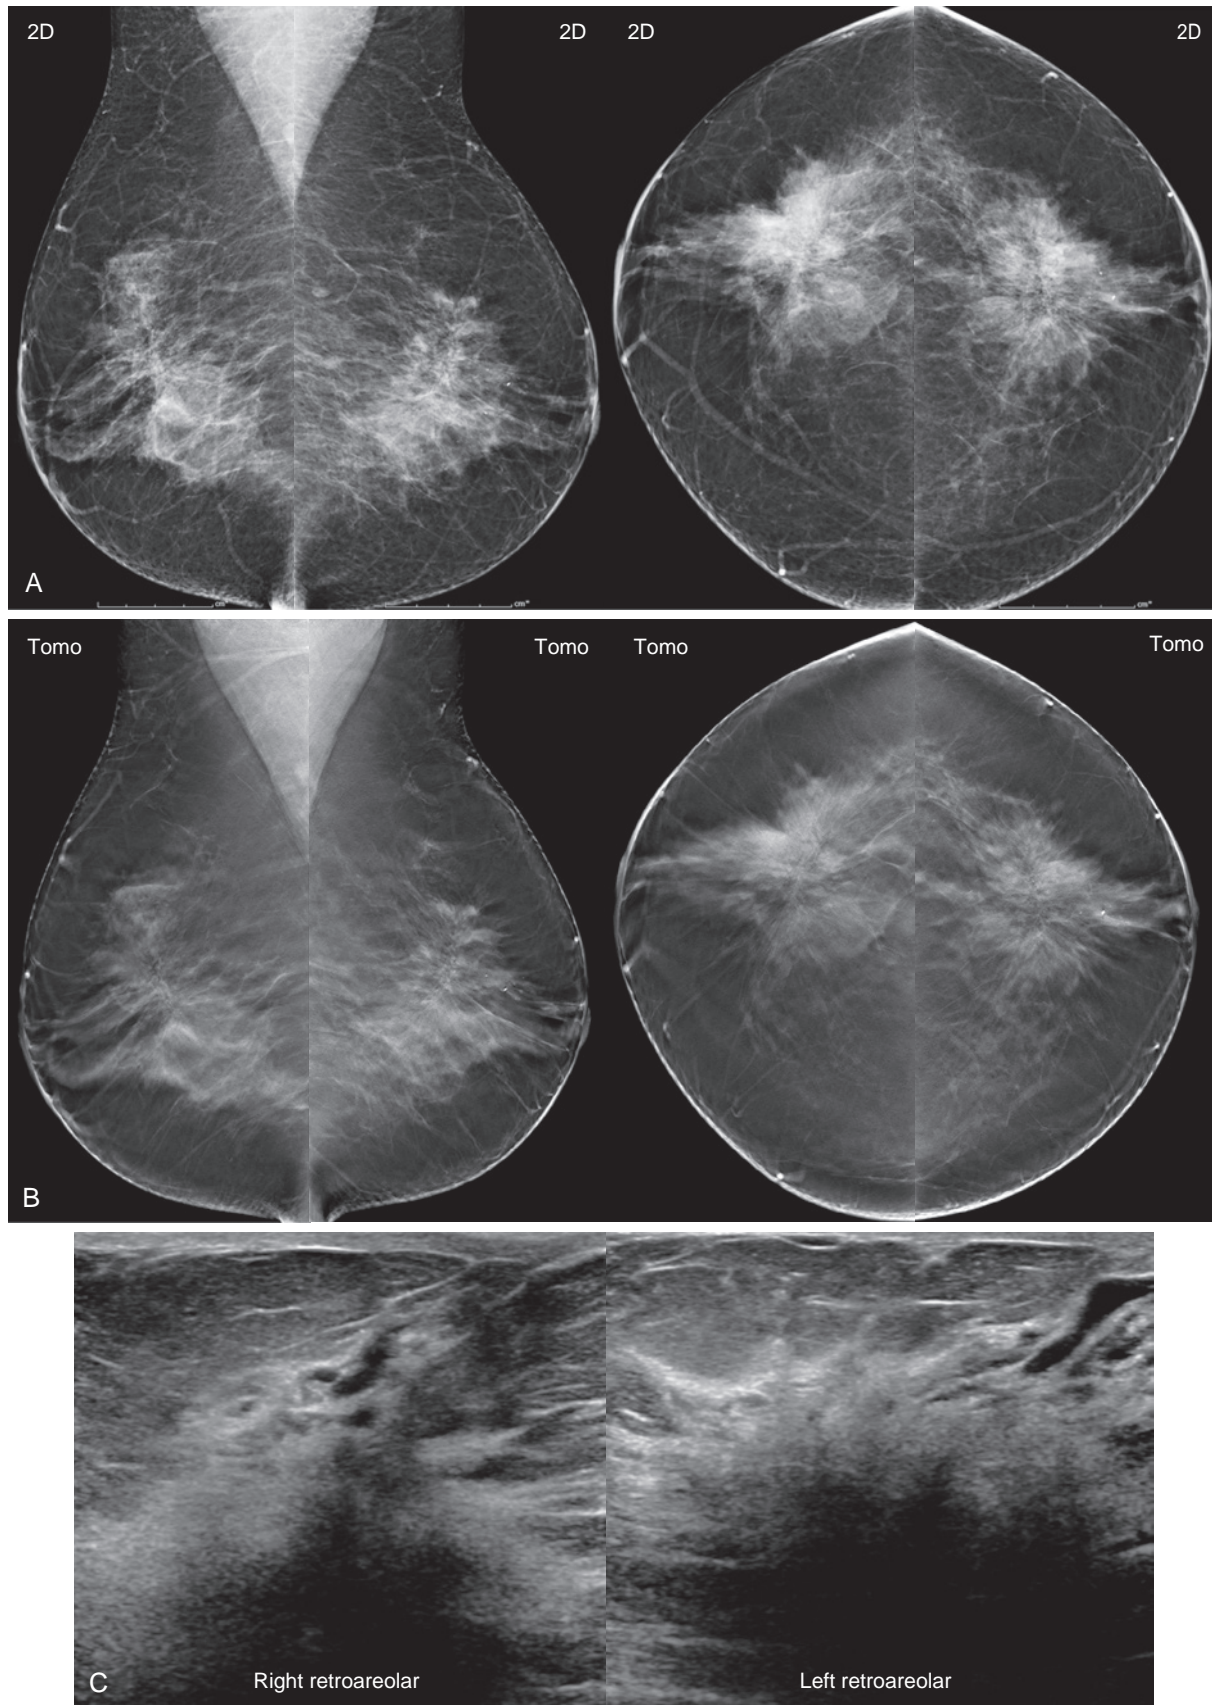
Bilateral benign architectural distortion (A) Baseline screening mammogram in a 44-year-old woman demonstrates bilateral architectural distortion, seen better on the craniocaudal views. (B) The bilateral architectural distortion is even more conspicuous on tomosynthesis. (C) Ultrasound (US) reveals diffuse irregular shadowing regions bilaterally, most prominent in the retroareolar regions. US-guided core needle biopsy revealed bilateral exuberant sclerosing adenosis and ductal hyperplasia, which was considered concordant after careful imaging-pathology correlation with the interpreting pathologist. The lesions were stable on subsequent imaging follow-up.
